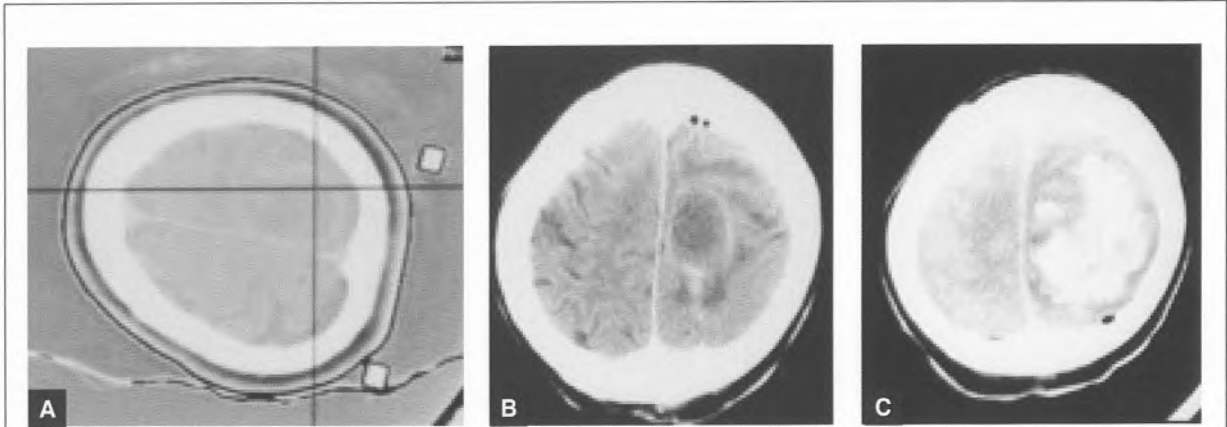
Axial CT scan showing the lesion on the first stereotactic planning scan (a); following a non-diagnostic biopsy, a thin tract is seen leading to the edge of the lesion (b). CT scan obtained urgently following the patient's abrupt deterioration 2 hours after a second stereotactic biopsy showed a massive intracerebral haematoma (c)
